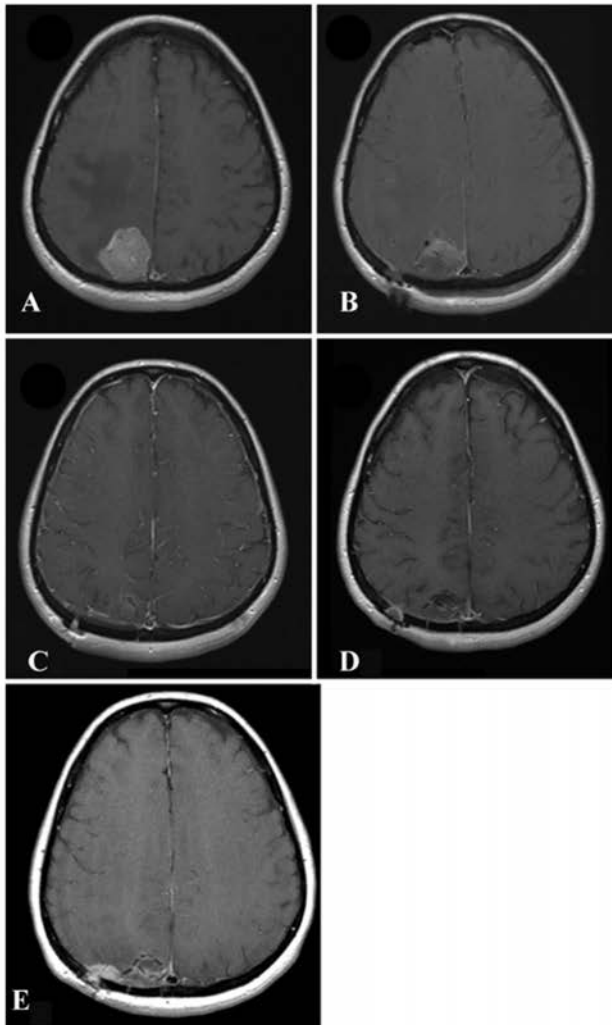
Magnetic resonance imaging series of regional recurrence. A: Preoperative. B: Postoperative. C: One month postoperative. D: Four months postoperative. E: Seven months postoperative.
